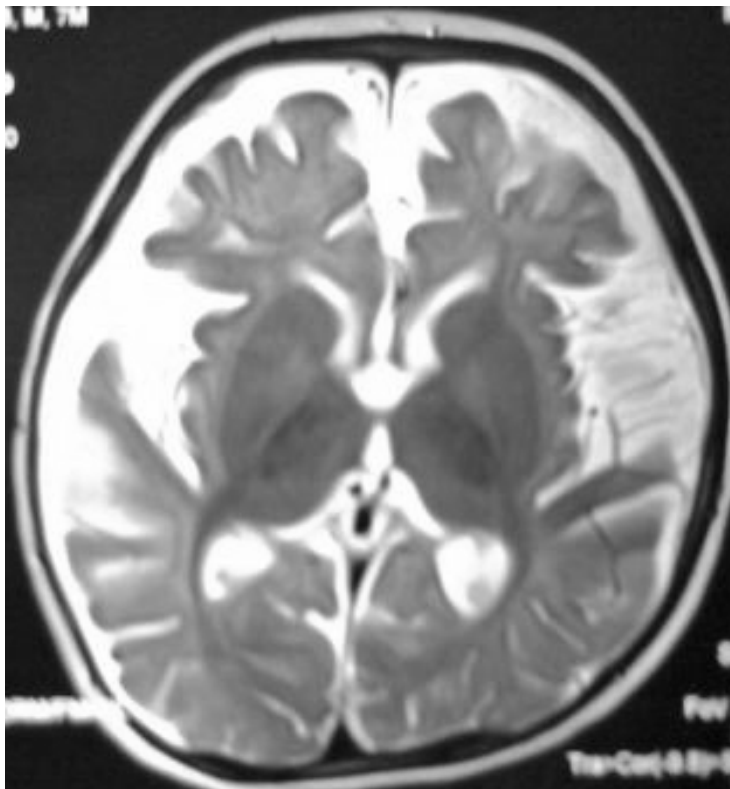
CT brain showing bat wing shaped frontal cortical atrophy
